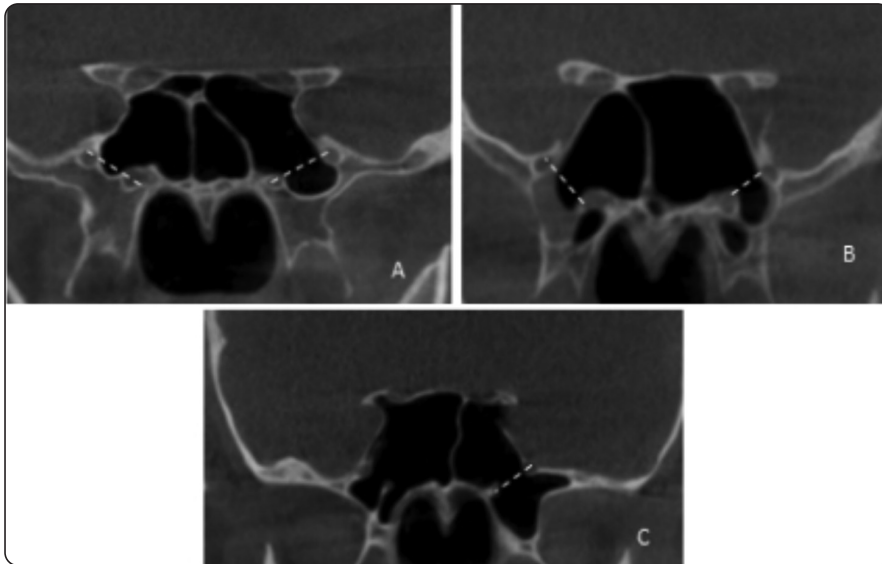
Coronal cuts of CBCT showing the lateral SS pneumatization, A: greater wing pneumatization on the left side, B: bilateral pterygoid pneumatization and C: bilateral full lateral pneumatization.
